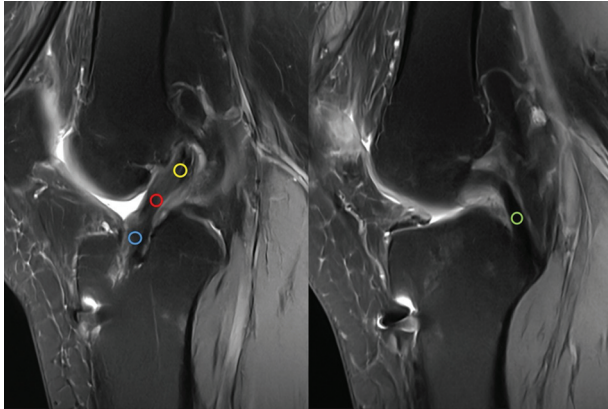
Representative sagittal T2-weighted magnetic resonance images demonstrating region of interest (ROI) placement for signal intensity ratio measurements. Circular ROIs were placed at the proximal (yellow), midsubstance (red), and distal (blue) portions of the intra-articular graft. A reference ROI was placed at the tibial insertion of the posterior cruciate ligament (PCL) (green). When the graft and PCL insertion were not visible on the same slice, measurements were obtained from adjacent sagittal slices demonstrating each structure.
